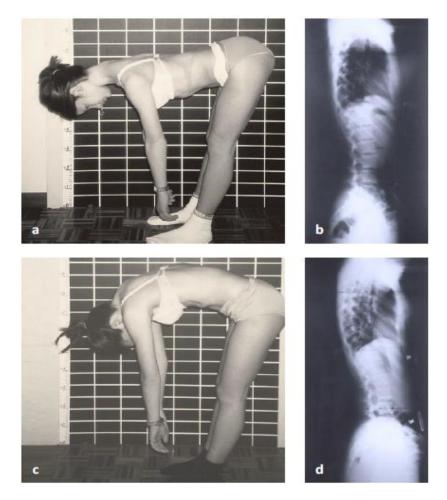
Stiffened extreme flatback (a), also visible on the x-ray (b), caused by improper brace treatment. Below (c and d): after twelve months of treatment with a Chêneau brace, nearly normal conditions are observable from the side (modified from Weiss, Rigo, Chêneau 2000).
